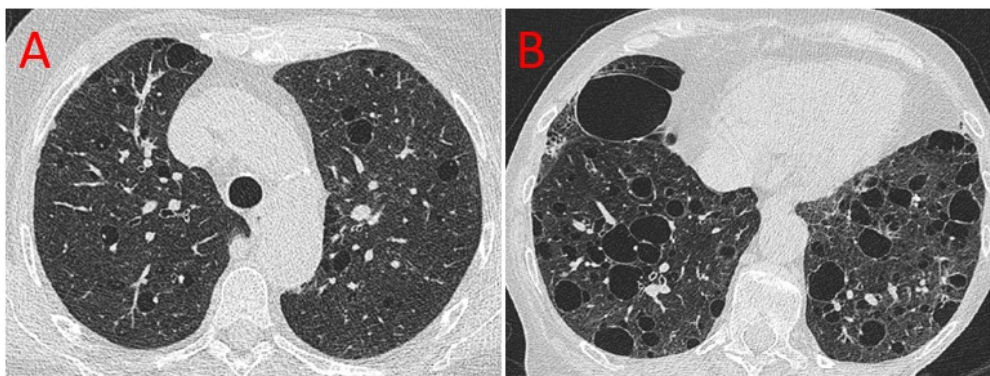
High resolution CT dicom's from a patient with Sjögren's syndrome from the ILD-PH cohort.
